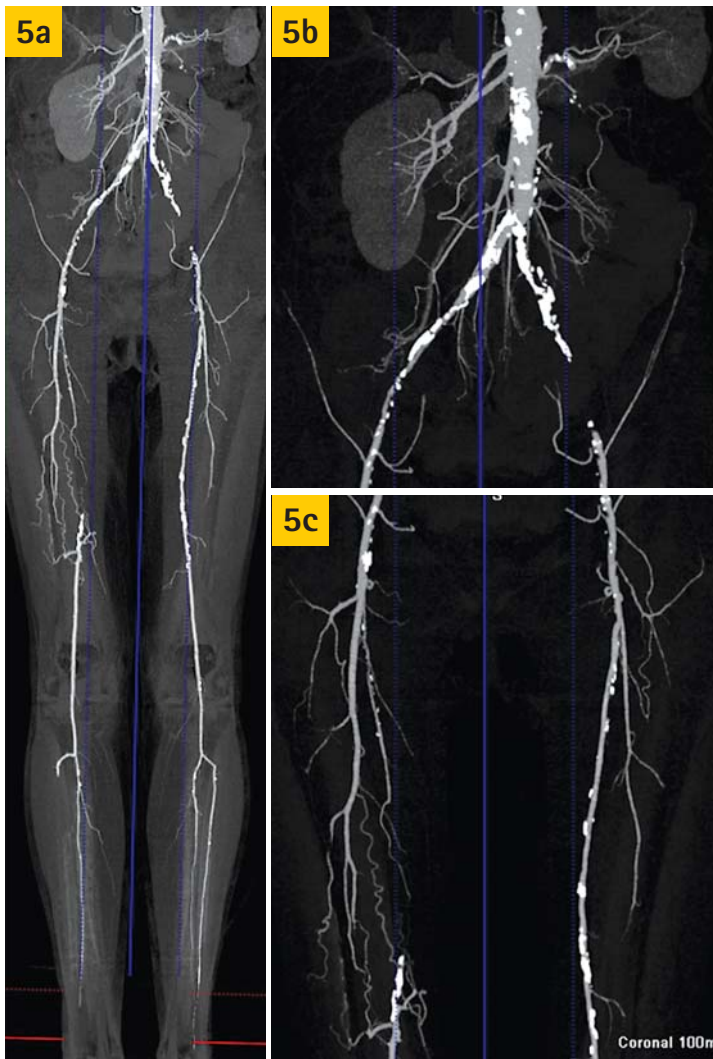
Pelvic/leg CT angiography with a) MIP overview, b) enlargement of the pelvic/leg segments confirming occlusion of the left arteria iliaca communis with sclerotic plaque and c) confirming an AFS occlusion in the area of the adductor canal in the right thigh.
